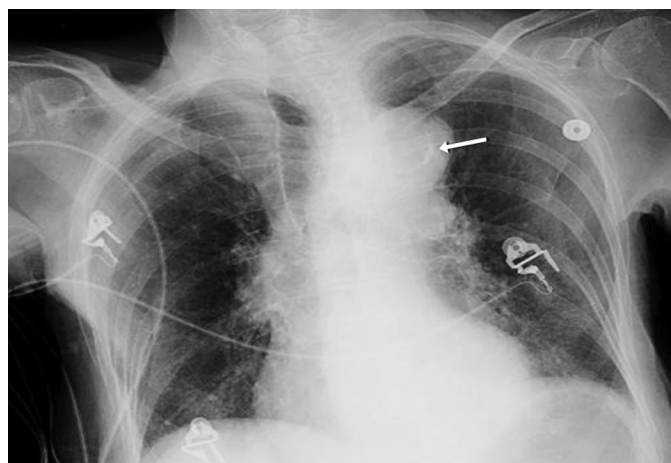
FIGURE e57-8 Chest radiograph of a patient with aortic dissection demonstrating an abnormal aortic knob with displaced intimal calcium (*arrow*), the "calcium sign."
